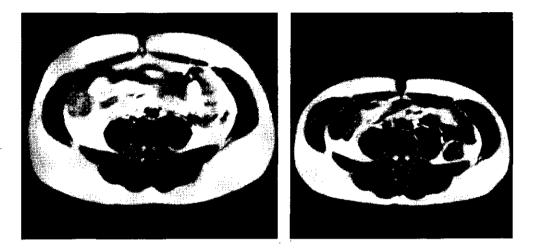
MRI scans at abdominal level before (left) and after weight loss (right).
